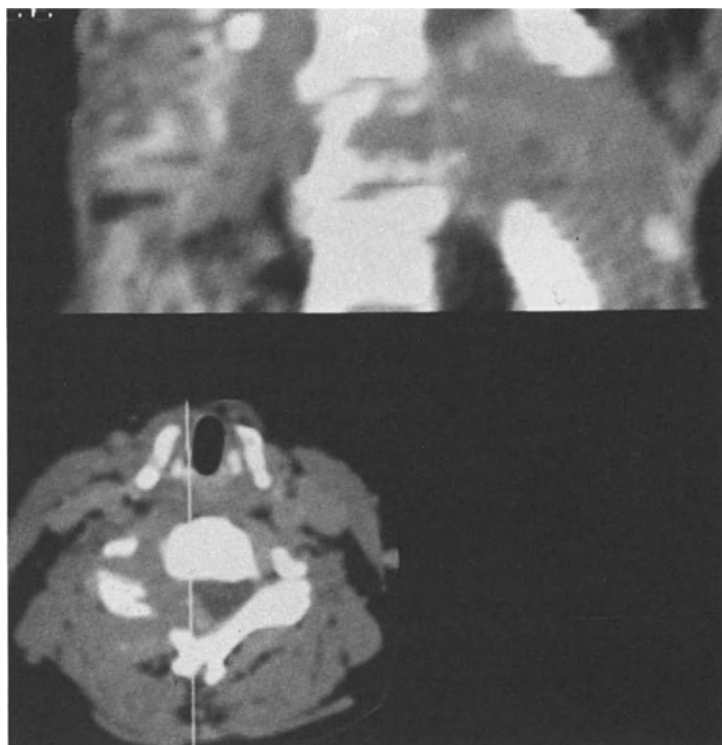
CT scan showing tumoral infiltration of the vertebral body and into the spinal canal
